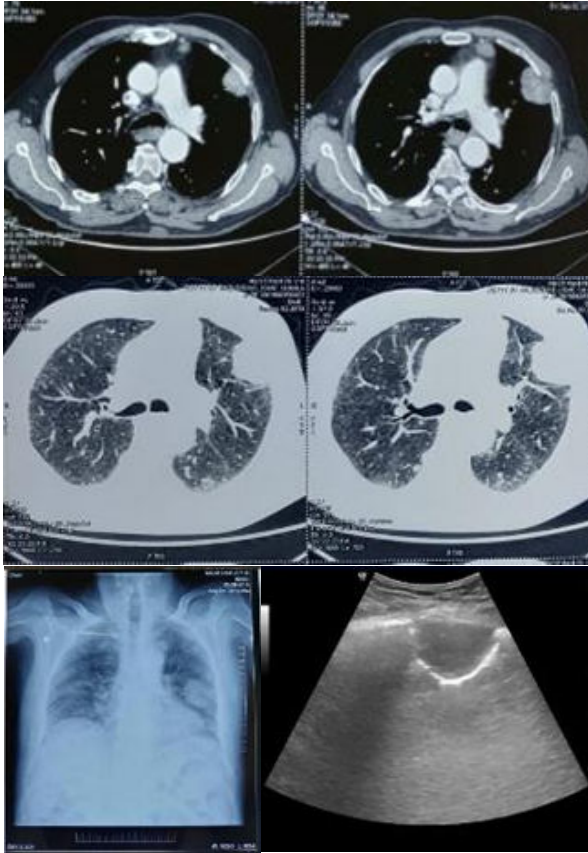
CECT thorax shows heterogeneously enhancing lobulated soft tissue mass in anterior segment of LUL with broad base towards pleura – Carcinoma left lung with? metastatic mediastinal lymphadenopathy. Chest radiograph shows oval mass lesion in left mid zone abutting thoracic cage .Sonography shows mass lesion abutting pleura .
